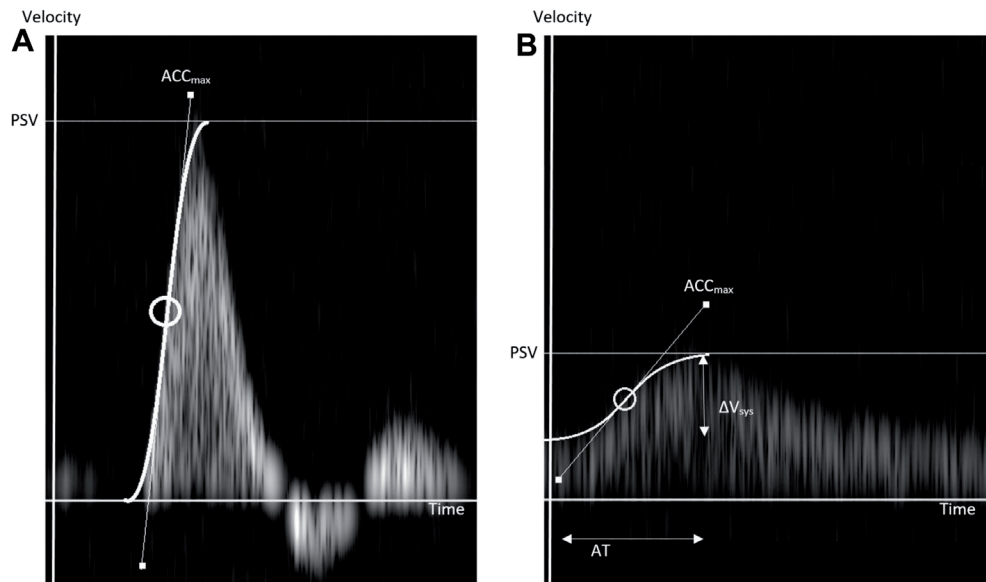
Example analysis of Doppler spectrum.
